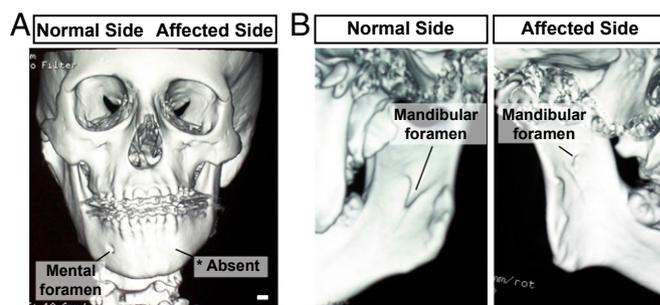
Vessel defects correlate with mandibular hypoplasia in hemifacial microsomia. (A) Computed tomography image of a 15-year-old male with a hypoplastic mandible on his left (affected) side. The mental foramen is absent on the affected side of the jaw. (B) Computed tomography images indicate the mandibular foramen is present on the unaffected side, but is distinctly smaller in diameter and mispositioned on the affected side. (Scale bar, 1 cm.)
